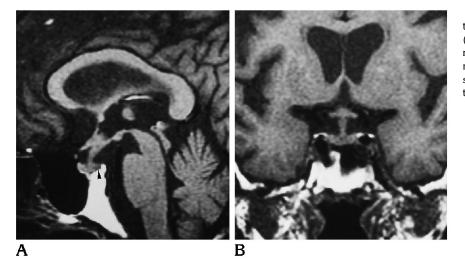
T1-weighted (350/20/4 [repetition time/echo time/excitations]) sagittal (*A*) and coronal (*B*) images show a symmetric thickened pituitary stalk. The posterior lobe shows absence of the normal high signal intensity and slightly lower signal intensity than the anterior lobe (*arrowhead*).
